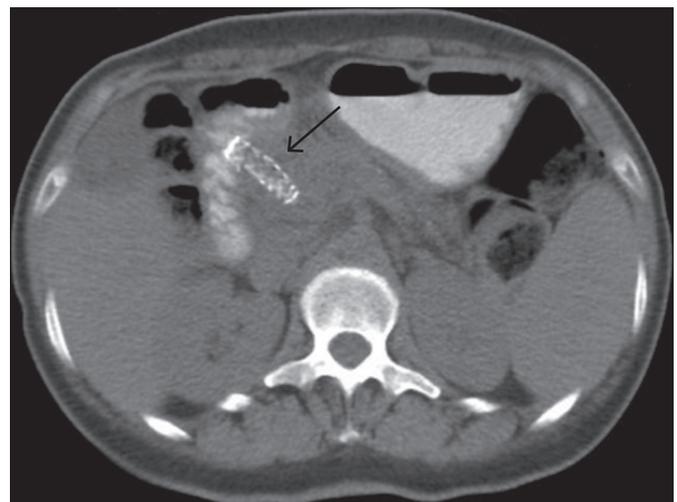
Contrast-enhanced axial CT imaging from 2015 (age 38) demonstrating a 10-mm \times 4-mm covered metal stent within distal common bile duct (arrow).
